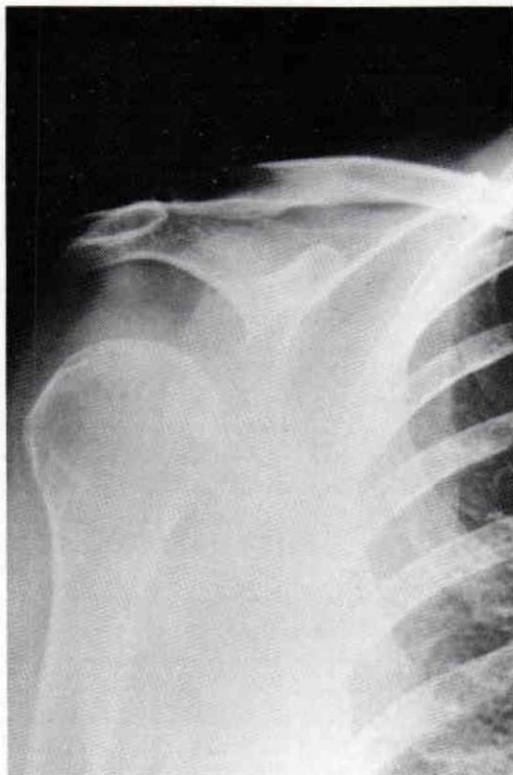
X-ray of patient in upright position demonstrates the degree of shoulder subluxation.
